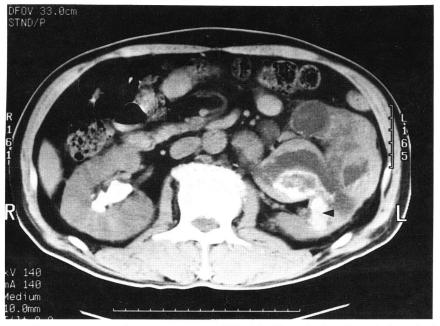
Abdominal CT shows a mass in the upper pole of the left kidney. It also shows hydronephrotic changes and parenchymal calcifications(arrowhead) in the left kidney.
